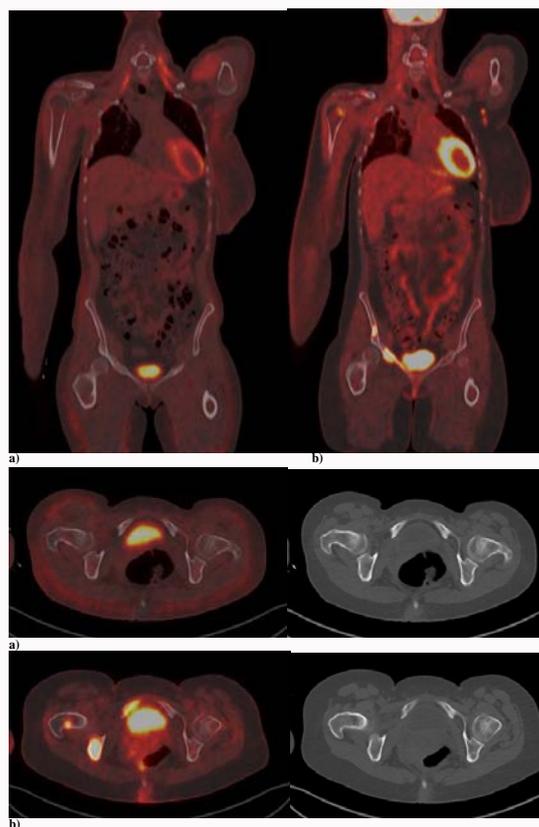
38 Year female with treated breast cancer on follow up. PET/CT images obtained at baseline (a) and follow up after treatment (b): Shows an absence of FDG avid disease on baseline, which remains unchanged on CT images and RECIST 1.1, however new FDG avid skeletal lesions are seen on PET with progressive metabolic disease with PERCIST 1.0.
